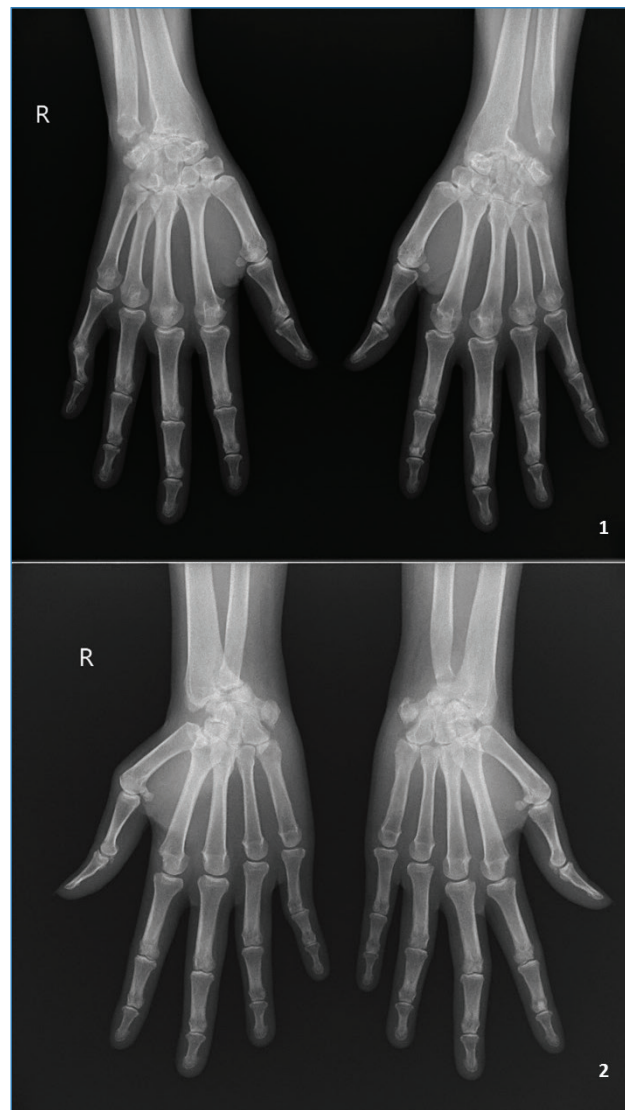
Radiograph of both hands (2 incidences)
